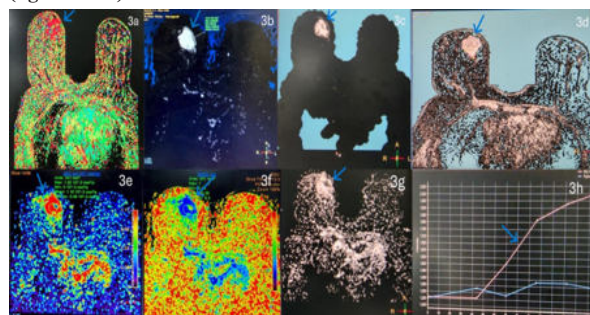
T1W perfusion imaging (3a&3b), Dynamic contrast enhancement imaging (3d) and dynamic contrast/kinetic curve (3h) showed a lesion in the right breast with Rapid uptake with Persistent and progressive enhancement. In DWI (3c) mass lesion appears hyperintense with Slight peripheral restriction on ADC images (3e-3g) with ADC value of 1.2×10^{-3}
